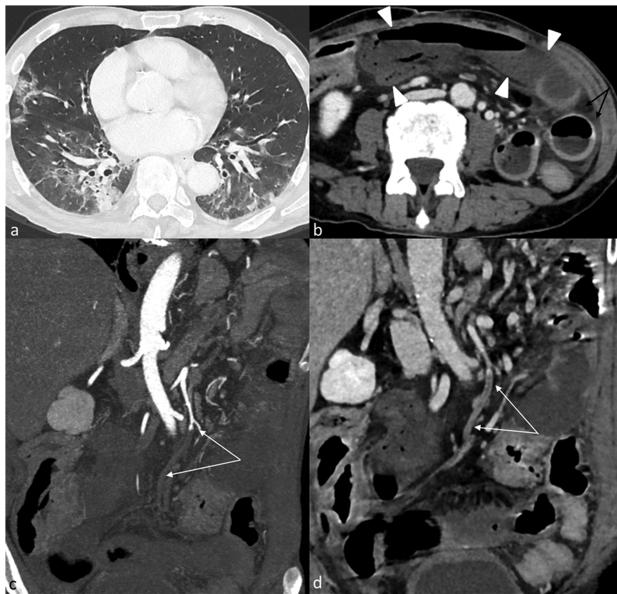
(a-d) CT scan of the chest (a) demonstrates bilateral opacities localized in peripheral and central parts of the lung, with prevalence of ground-glass pattern. In the abdomen (b), multiple small bowel loops are dilated and contain air-fluid levels; thinning of the walls and absence of contrast enhancement (arrowheads) indicate ischemia. Edema of the mesenteric fat and a small fluid collection are also seen (black arrow in b). Paracoronal reconstructions show occlusion of the superior mesenteric artery (arrows in c) due to thromboembolism, with associated late enhancement of the arterial walls in the equilibrium phase (arrows in d), suggestive for inflammation.
